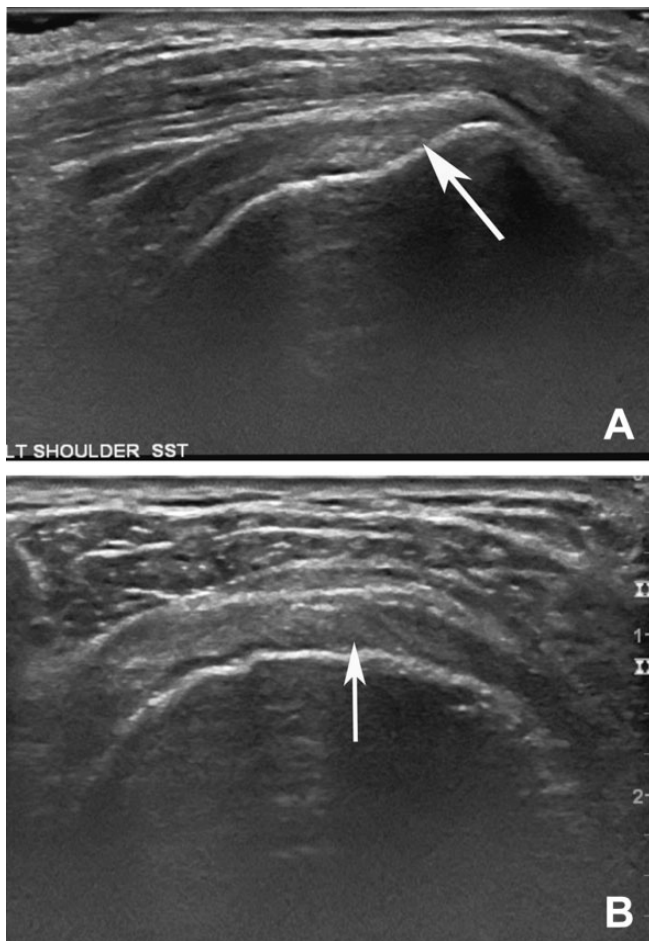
Ultrasound (A) long-axis and (B) short-axis views of an intact healed supraspinatus tendon intact without tear. Arrows indicate location of repair with intact healed rotator cuff tendon.
